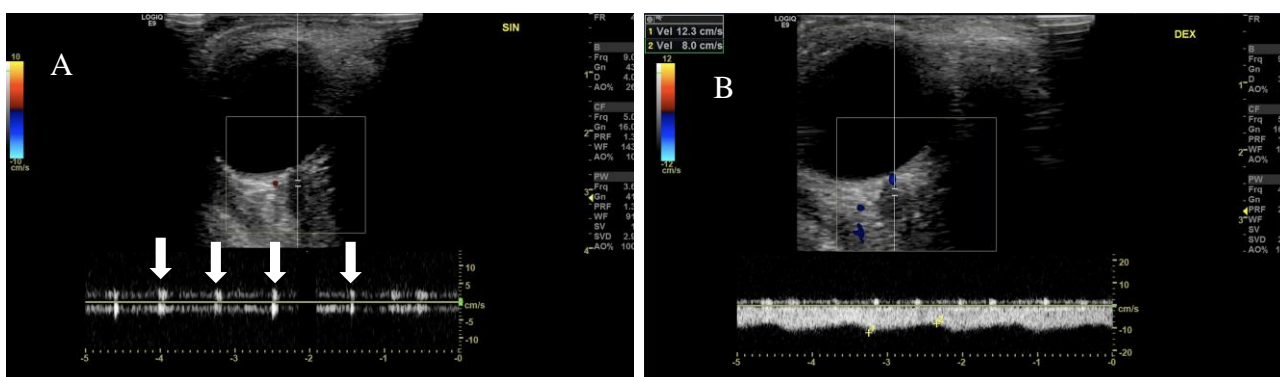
Transorbital color-coded duplex sonography of bilateral CRAOs, confirmed by an ophthalmologist.
